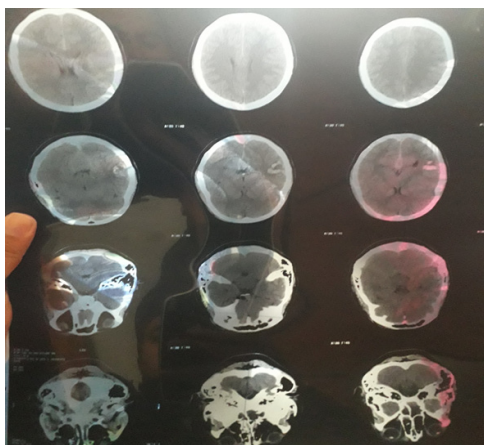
Hematoma with heterogeneous density, CT, taken in the first 4 hours of the condition.
